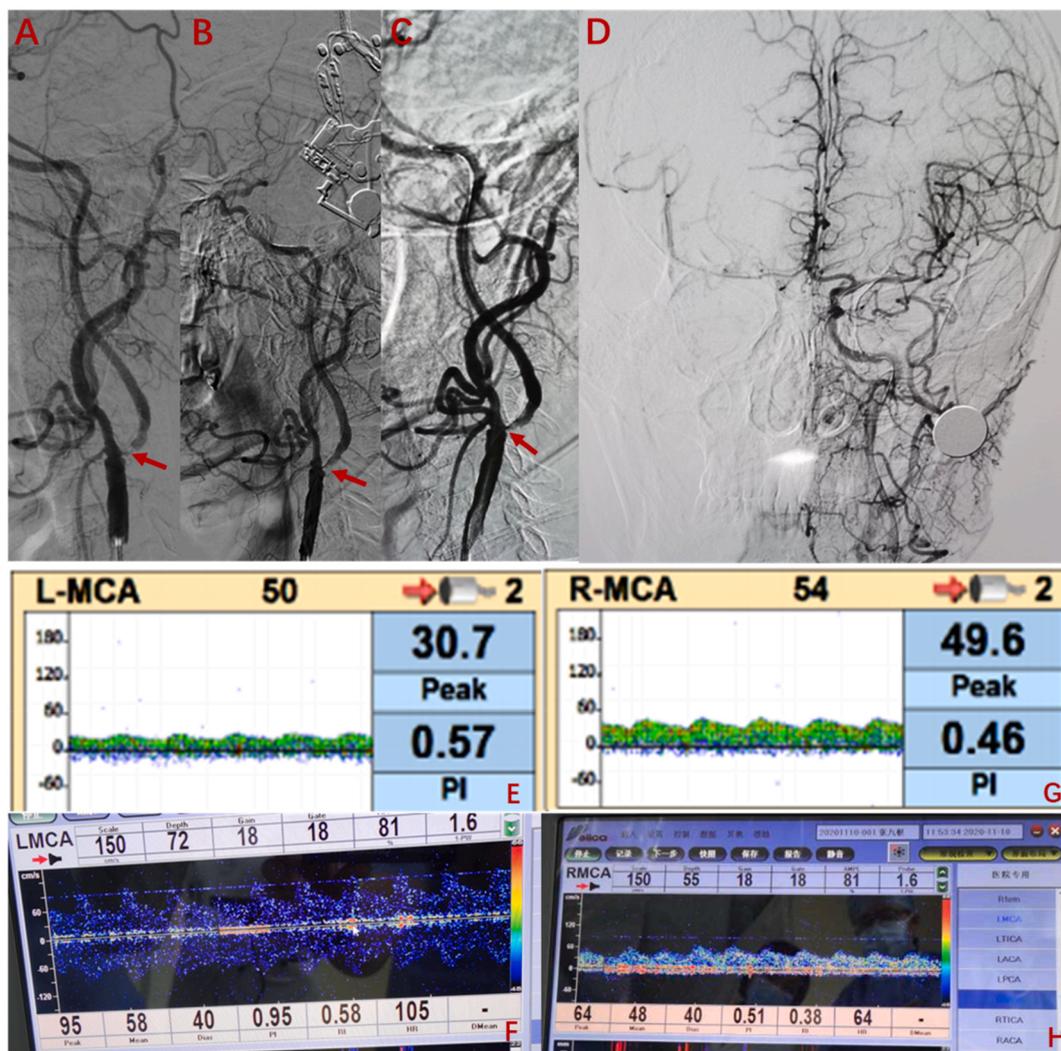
The digital subtraction angiography (DSA) and transcranial doppler (TCD) of the patient. (A) The initial segment of bilateral internal carotid artery (ICA) were subtotal occlusion before balloon dilation; (B) The first time for 2.0 mm × 15 mm Sprinter balloon dilated the stenosis; (C–D): The second time for 3.0 × 15 mm Sprinter balloon dilated the stenosis; (E): The mean velocity (Vm) and systolic velocity (Vs) of the left middle cerebral artery (MCA) before surgery measured by intraoperative TCD; (F) The TCD showed the postoperative Vm of the left MCA reached 58cm/s and the Vs was 95cm/s; (G) The Vm and Vs of the right MCA before surgery measured by TCD; (H) The Vm and Vs of the right MCA before surgery measured by TCD after the surgery.
